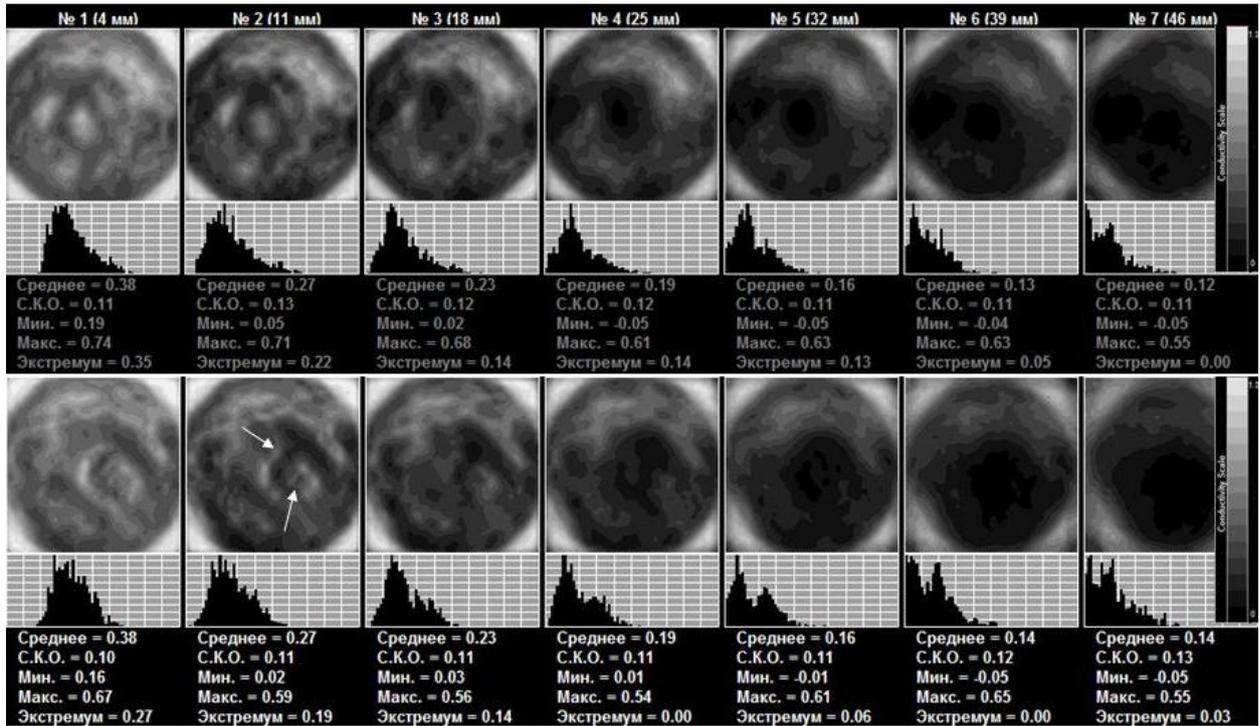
EIM. Top row – left gland. Ductal type of mammary gland structure. Lower row – right gland. Ductal type of mammary gland structure. The anatomy of the areolar area is altered. Hyper-impedance contour. ULTRASOUND: Areolar oedema characters in the right. Roentgenogram: In areolar and nipple area on the right, there is an area with irregular blurred contours, emerging above the surface.
